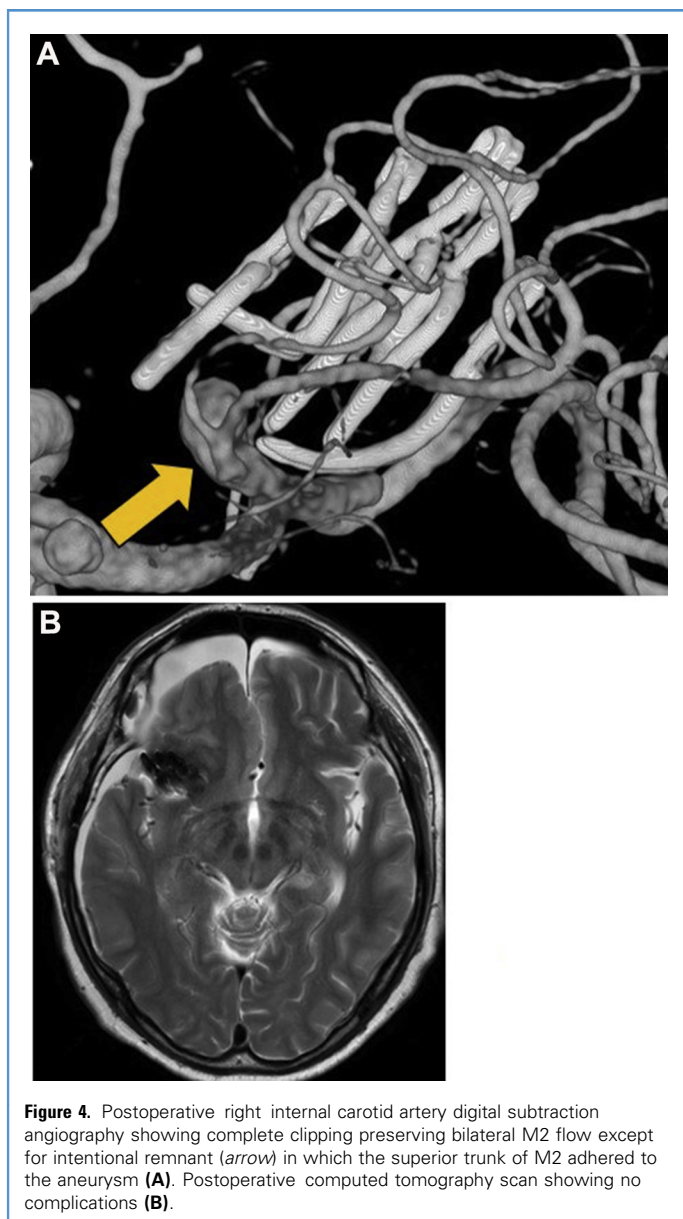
Postoperative right internal carotid artery digital subtraction angiography showing complete clipping preserving bilateral M2 flow except for intentional remnant (arrow) in which the superior trunk of M2 adhered to the aneurysm (A). Postoperative computed tomography scan showing no complications (B).
